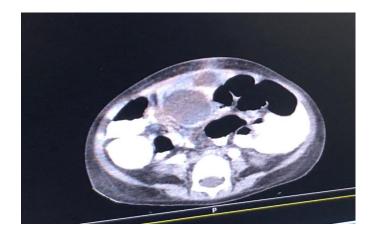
CT scan of abdomen and pelvis with intravenous contrast obtained at time of admission of the patient described in the case report. A large, well-circumscribed mass is seen located near the anterior abdominal wall to the right of midline. This mass has cystic characteristics and contains fluid. Inflammatory changes can be seen surrounding this mass.
